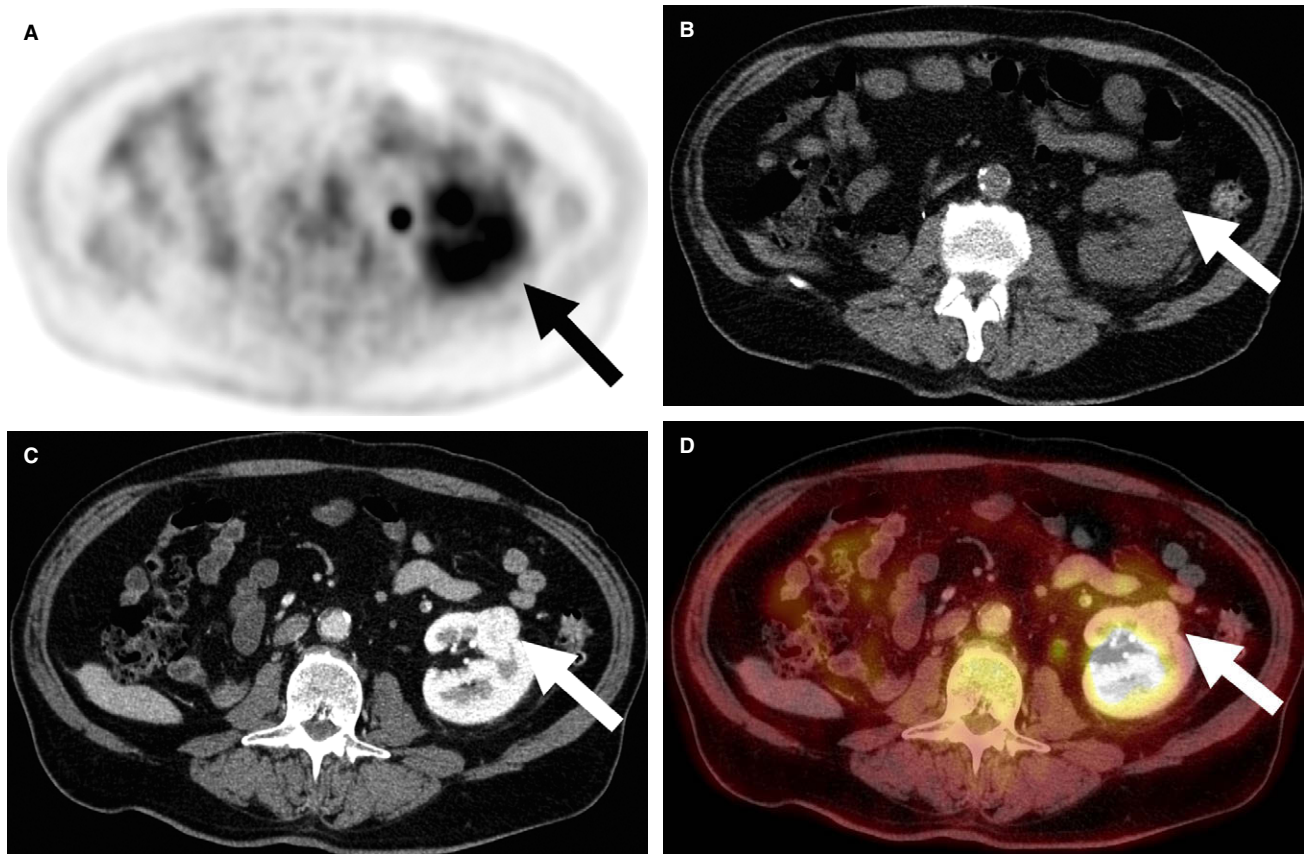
A 70-year-old with a history of renal cell carcinoma treated with right nephrectomy. (A) PET demonstrates normal FDG excretion in the left kidney (arrow). (B) Low-dose CT demonstrates a hyperdense lesion in the left kidney (arrow), which is incompletely characterized. (C) Contrast-enhanced CT
